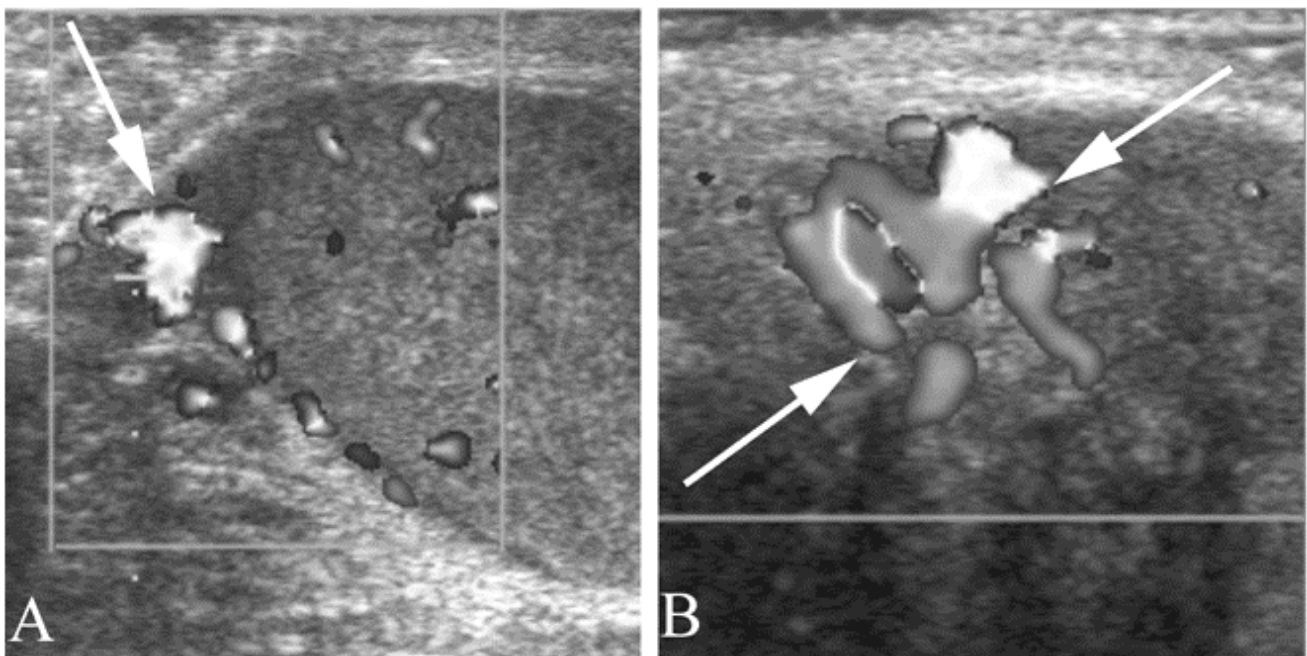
Epididymitis in a 14 year old with three days of scrotal pain. A. Ultrasound with color Doppler of the asymptomatic side shows a normal sized epididymis with normal flow (arrow). B. Ultrasound with color Doppler of the symptomatic side shows swelling and hyperemia of the epididymis, with increased flow (arrow).
